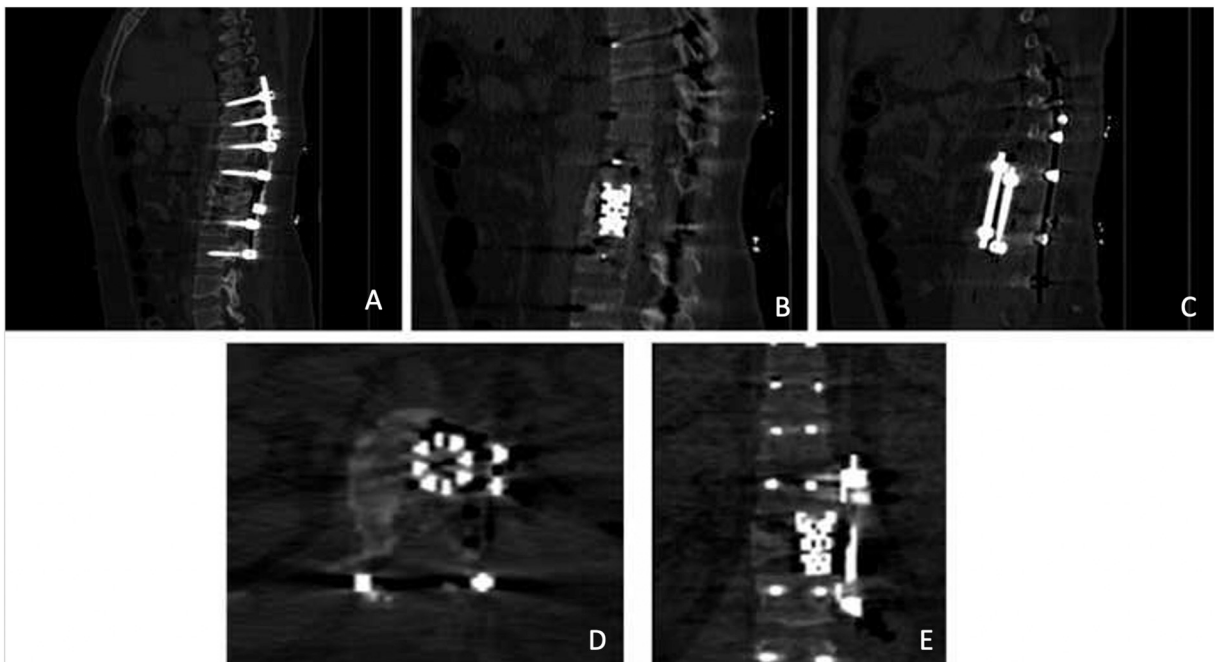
Postoperative CT scan of both anterior and posterior instrumentation. 5A. Sagittal view of posterior instrumentation via 12 screws, 2 rods and 2 connectors between T9-L3 segments. 5B. Sagittal view with dynamic expandable cage filled with autograft after corpectomy of L1 vertebra. 5C. Sagittal view of anterior dual-rod system inserted within plaques on T12 and L2 vertebral bodies. 5D. Axial view of anterior dynamic expandable cage and dual-rod system. 5E. Coronal view of anterior dynamic expandable cage and dual rod system.
